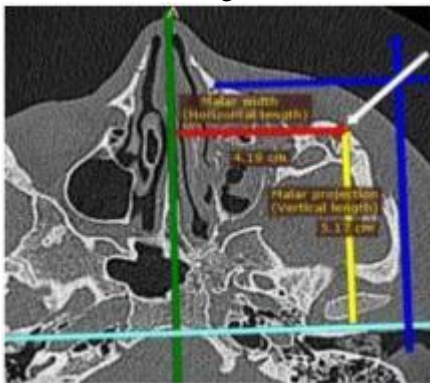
Preoperative radiographic malar width and malar projection on the fracture side.
